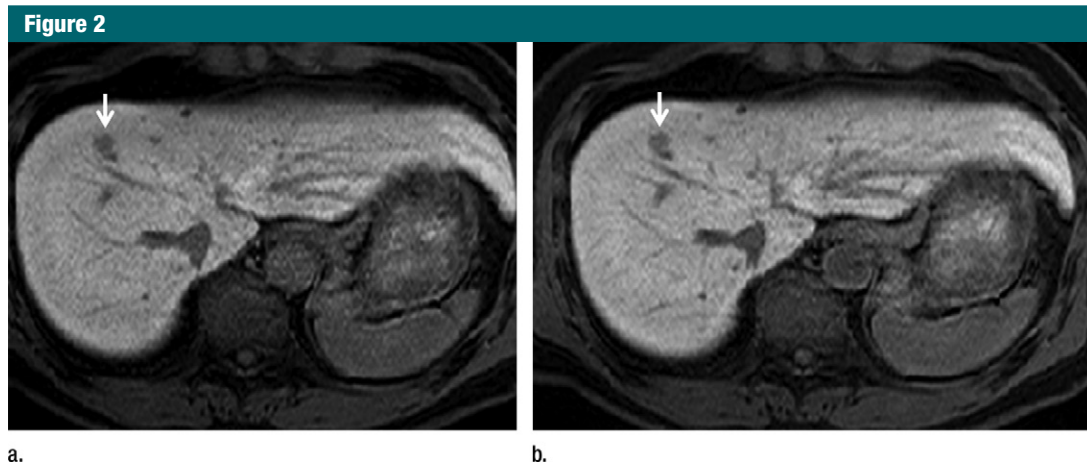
Axial MR images of HCC (arrow) in liver segment 8 in a 58-year-old man. Hepatobiliary phase Gd-EOB-DTPA-enhanced MR images were obtained at (a) 10 minutes and (b) 20 minutes. The LSC of HCC was 1.54 at 10 minutes (a) and 1.68 at 20 minutes (b), and the liver enhancement increased from 10 minutes to 20 minutes. The LLC of HCC was 0.67 at 10 minutes (a) and 0.63 at 20 minutes (b). Parameters related to liver function are AST level, 28 IU/L (0.47 μ kat/L); ALT level, 20 IU/L (0.3 μ kat/L); albumin level, 4.8 g/dL (48 g/L); total bilirubin level, 0.3 mg/dL (5.1 μ mol/L); PT activity, 108.9%; total protein level, 7.1 g/dL (71 g/L); alkaline phosphatase level, 211 IU/L (3.5 μ kat/L); γ -glutamyl transpeptidase level, 38 IU/L; lactate dehydrogenase level, 216 IU/L (3.6 μ kat/L); blood urea nitrogen level, 18 mg/dL (6.4 mmol/L); serum creatinine level, 0.75 mg/dL (66.3 μ mol/L); PT time, 11.3 seconds, and Child-Pugh classification A.
